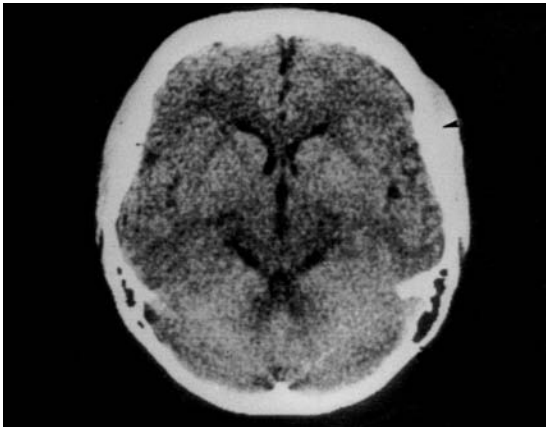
Case 1. Horizontal CT section showing swelling of left temporal muscle.
